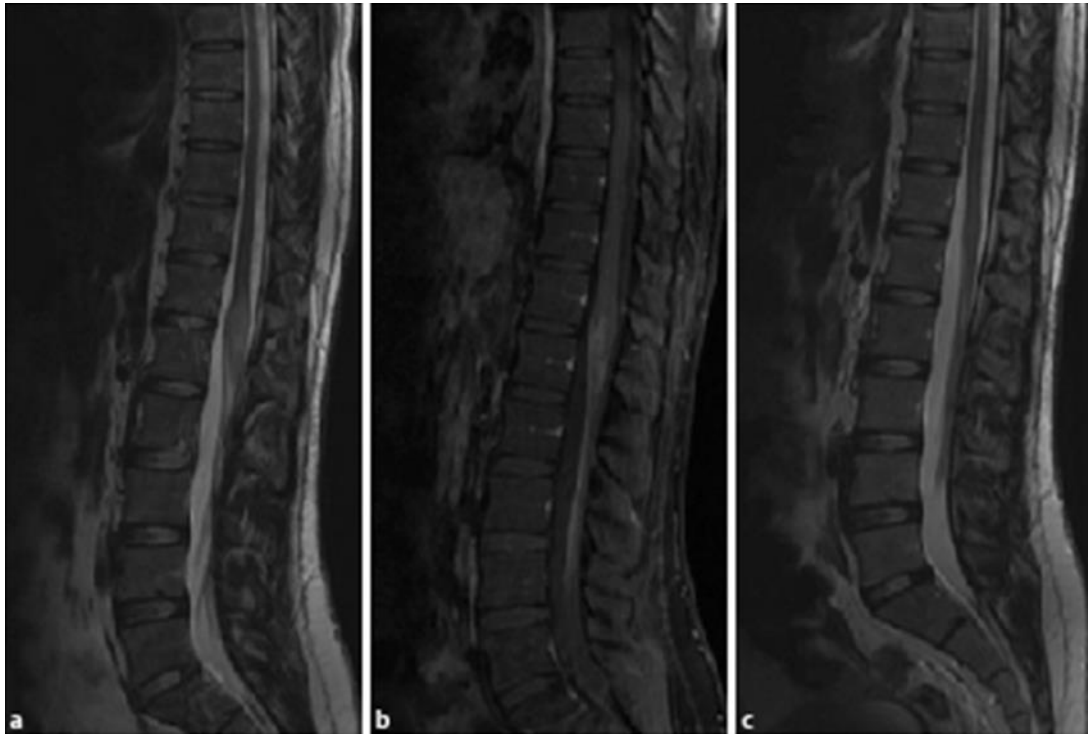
a T2 sagittal MRI of the thoracolumbar spine at the time of admission demonstrates swelling of the conus medullaris which enhances heterogeneously after contrast (b). c T2 sagittal MRI of the spine of the same patient after treatment, showing marked interval reduction in the size of the swelling, denoting treatment response (case 2).
